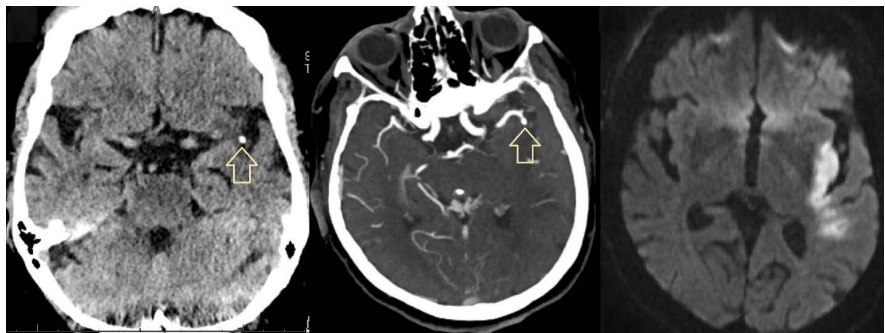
“Dot” sign of the left Middle Cerebral Artery (MCA). An 85-y/o patient who, after a fall, was noticed to be nonverbal and with right hemiparesis. CT (left image) and CTA (middle) show the “dot sign” (arrows) with flow void in the M2 branch of the Left MCA. There is hyperdensity on diffusion-weighted images (DWI) in the left insula (right).
